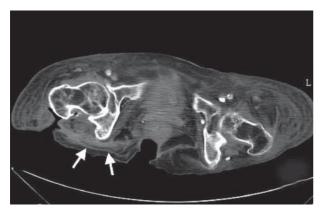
Postoperative CT showed open skin and muscle defect over right posterior thigh region near right interchanter was noted and the previous fistula with surrounding fatty infiltration was also noted which compatable with imflammatory process (arrows)
